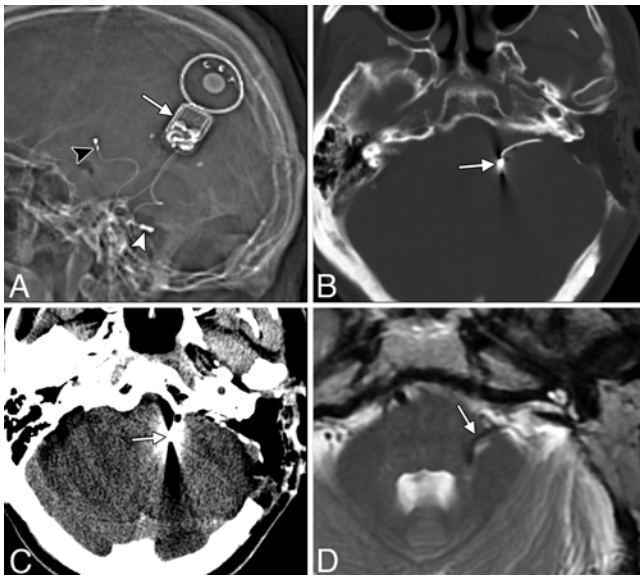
Auditory brainstem implant. A: Scout image showing the components of the device, including the receiver stimulator (arrow), stimulator electrode (white arrowhead), and grounding electrode (black arrowhead). B and C: Axial CT images in the bone (B) and soft-tissue (C) windows showing that the electrode (arrows) produces considerable streak artifact, which makes precise localization difficult. D: The position of the electrode (arrow) is better delineated on the axial T2-weighted MRI.
